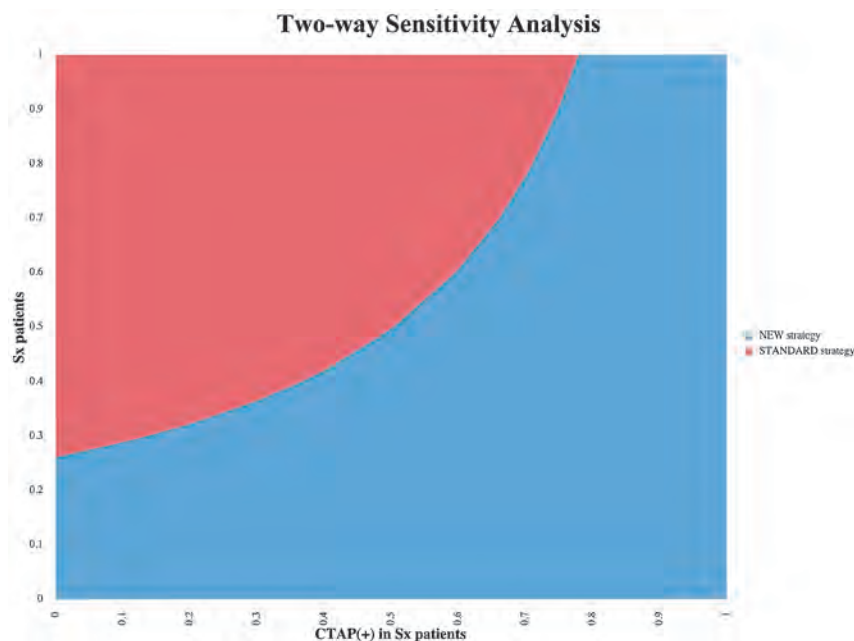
Multivariable (2-way) sensitivity analysis graph demonstrating how the decision depends on the values of the probability of positive findings on a CTA and CTP examination in symptomatic patients (Sx) and the probability of symptoms in the SAH population across all ranges. The new strategy represents CTAP imaging, and the standard strategy represents TCD imaging.
